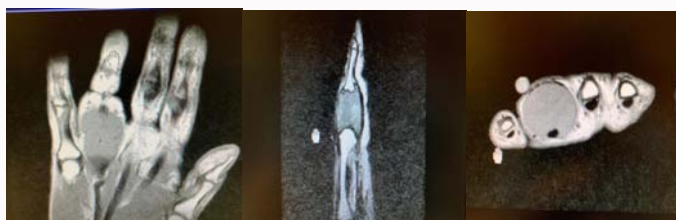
MRI of the left hand showing nonspecific 2.6 by 2.6 by 2.2 cm expansile osseous lesion in the proximal 4th digit.
